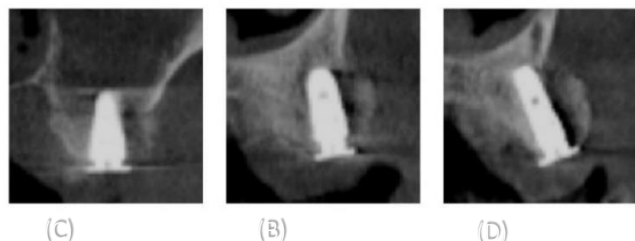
Immediate postoperative CBCT evaluation.
